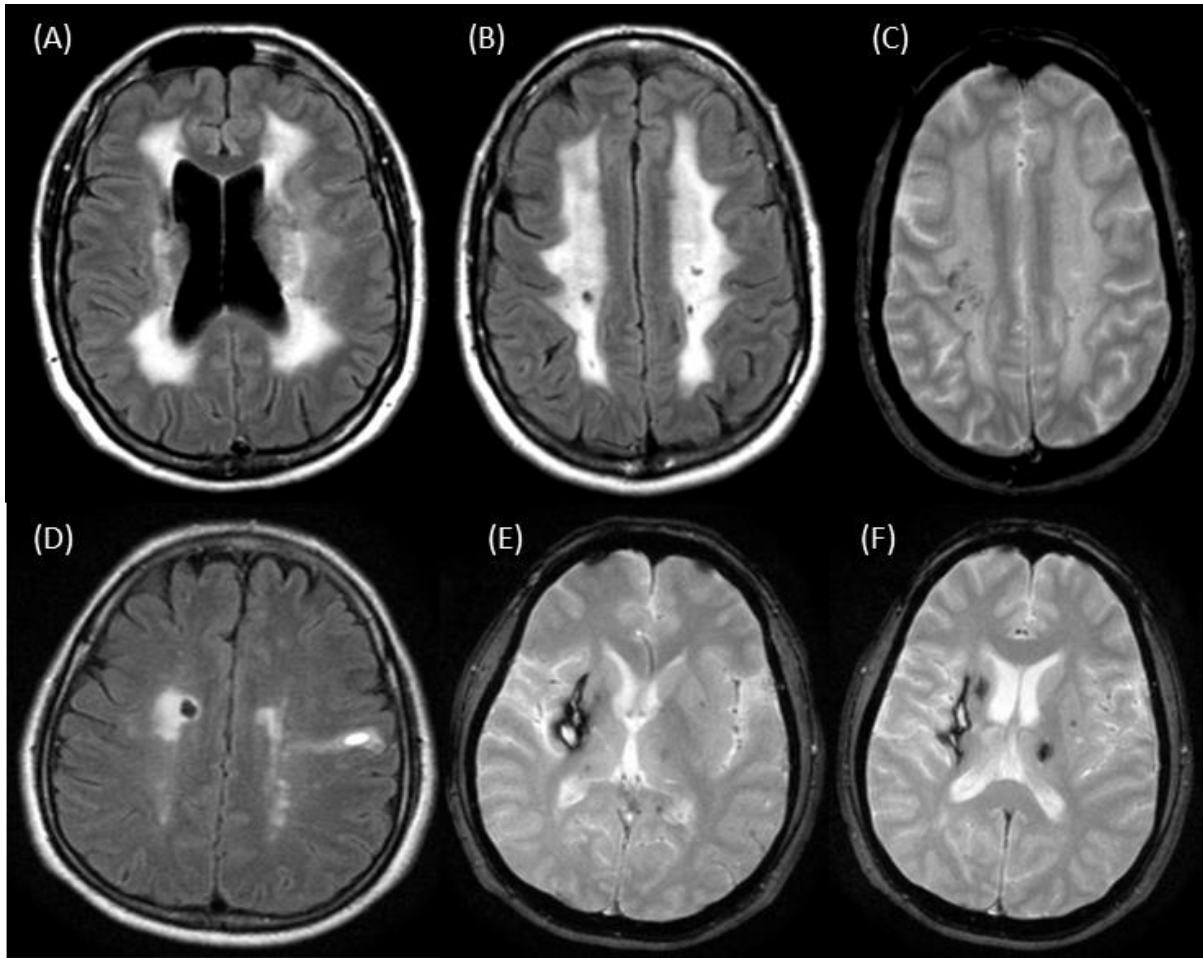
MRI appearances in two patients (A-C and D-F) with COL4A1 mutations. T2/FLAIR sequences show confluent white matter hyperintensities (A,B,D). T2* GRE sequences show cortical-subcortical microbleeds (C,F) and a previous haemorrhage (E,F)
